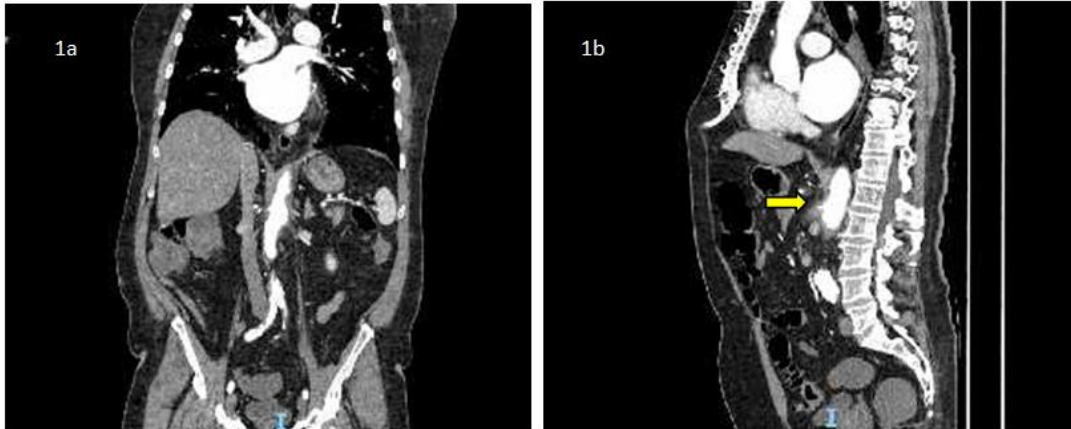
Contrast enhanced CT CAP coronal view demonstrating IgG4 related periaortic inflammation. Fig. 1b. CT CAP sagittal view with evidence of inflammation around the SMA origin with associated mural thickening (solid arrow)
